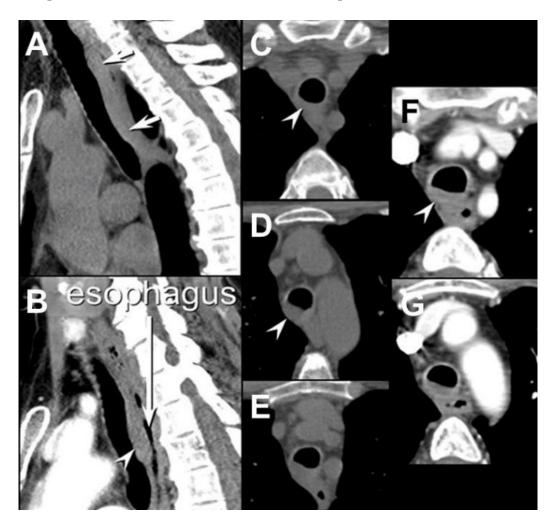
Selected views from the thoracic CT scan showing focal thickening of the posterior wall of the trachea (arrowheads). The thickening is best seen on the sagittal image (Panels A and B, arrows) posterior wall of the trachea (arrowheads). image (Panels A and B, arrows).
